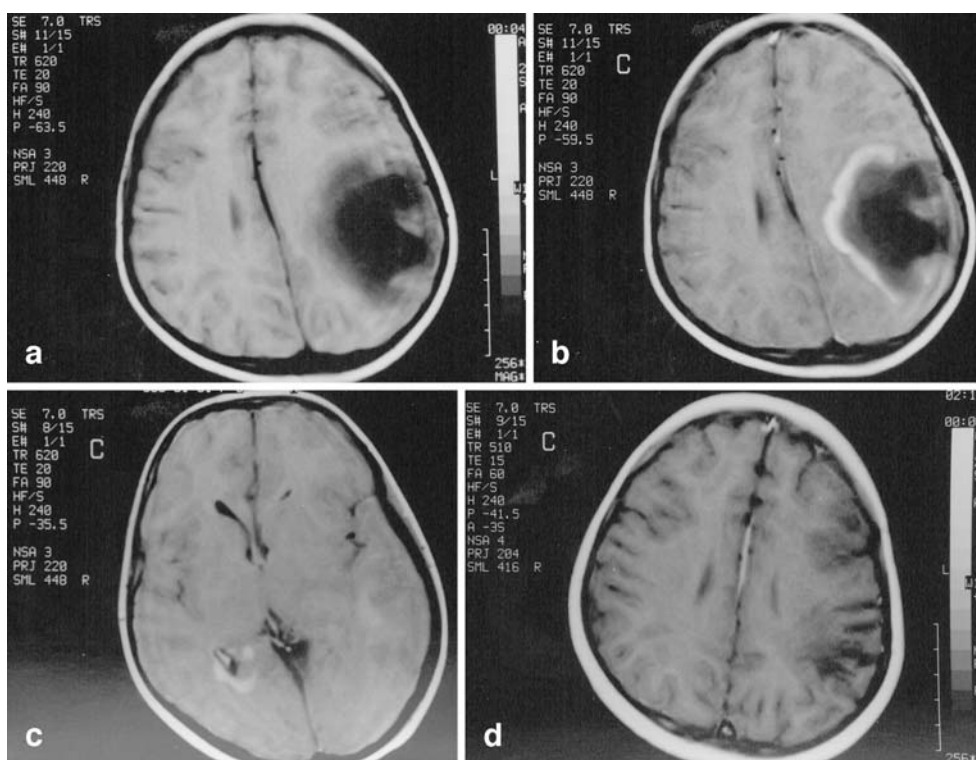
Case 1: Spin-echo T1-weighted axial image (a) shows hypo-intense large lesion on the right parietal white matter and a contrast-enhanced T1-weighted axial image (b) demonstrates hypo-intensity and peripheral half-rim enhancement. c Case 1: Spin-echo T1-weighted axial image with intravenous gadolinium-DTPA; 3 months after the treatment shows no contrast enhancement focal hypo-intensity on the right parietal region
